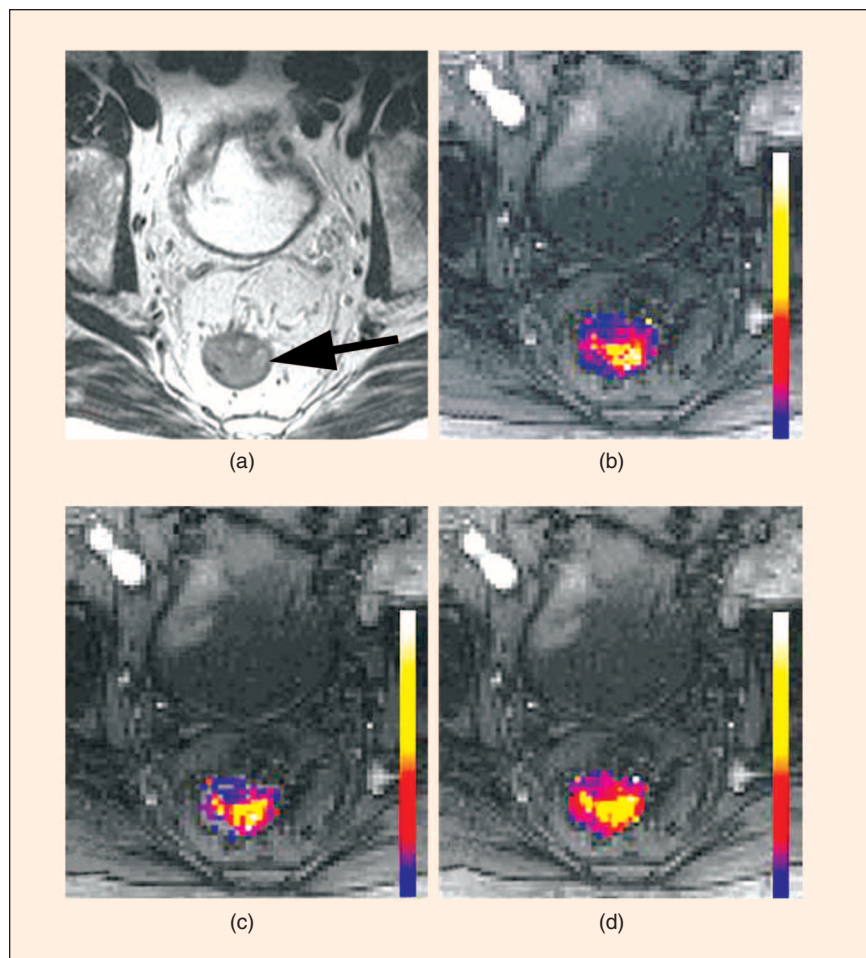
Rectal cancer: modeling approaches compared. (a) Anatomical T2-weighted image of a rectal cancer (arrow). Parametric images of the rate constant (k_{ep}) derived from the same data using three different model approaches. (b) General response. (c) Tofts' model using standard vascular input function. (d) Tofts' model using the Larsson model with an input function obtained from the external iliac artery. A high degree of concordance between the images is seen.
